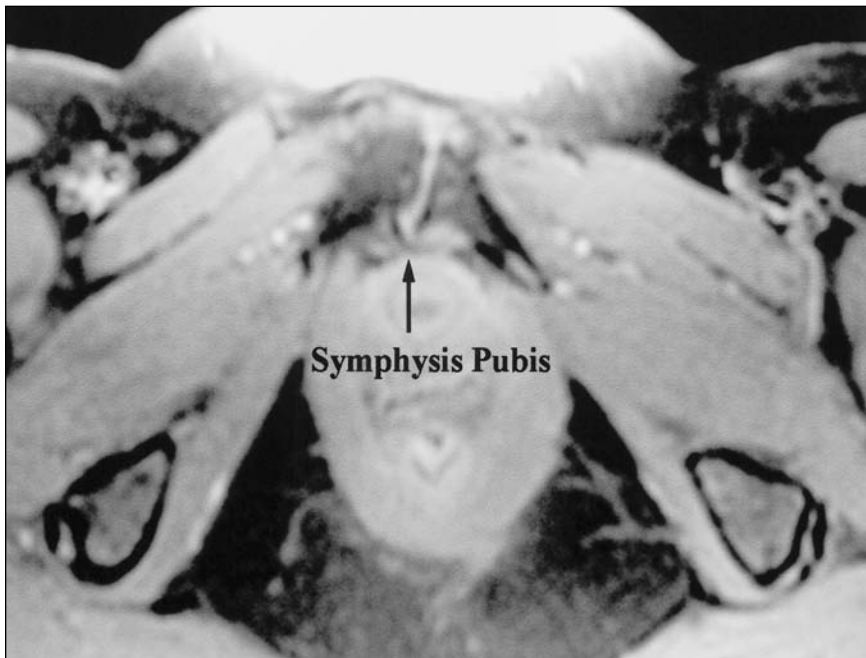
T₂-weighted MR image of the pelvis demonstrates an irregular joint line, mild soft-tissue reaction anteriorly but no bone marrow edema.
